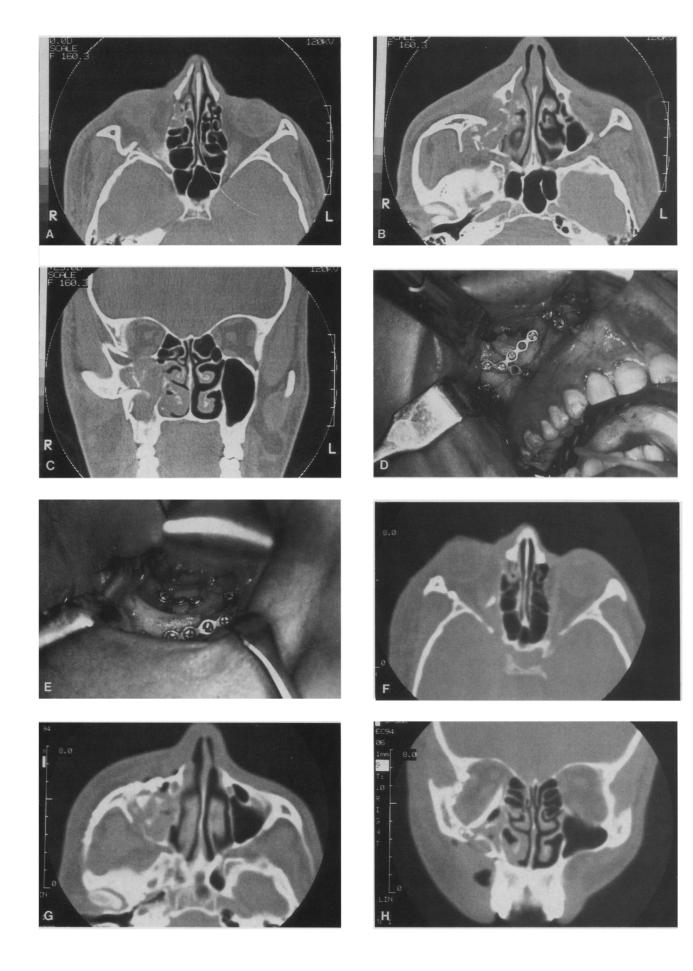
Treatment of patient with high-energy ZMC fracture by maxillary vestibular, subciliary, and coronal approaches. A-C, CT scans before surgery. Note comminution of articulations along lateral orbital wall and zygomaticomaxillary buttress, disarticulation of zygomatic arch from temporal process of zygomatic arch, and significant displacement of malar eminence. D, Intraoperative view showing reduction and fixation of zygomaticomaxillary buttress, using fractured pieces of bone to reconstruct skeleton. E, Internal orbit reconstructed with two pieces of bone, one along medial wall, one along floor. All pieces were stabilized with plate and screw fixation. The lateral orbital wall was also reconstructed by replacing and stabilizing fractured segment of bone at sphenozygomatic junction. F-H, Immediate postoperative CT scans showing reduction. I, J, Appearance of patient 8 weeks after surgery.
